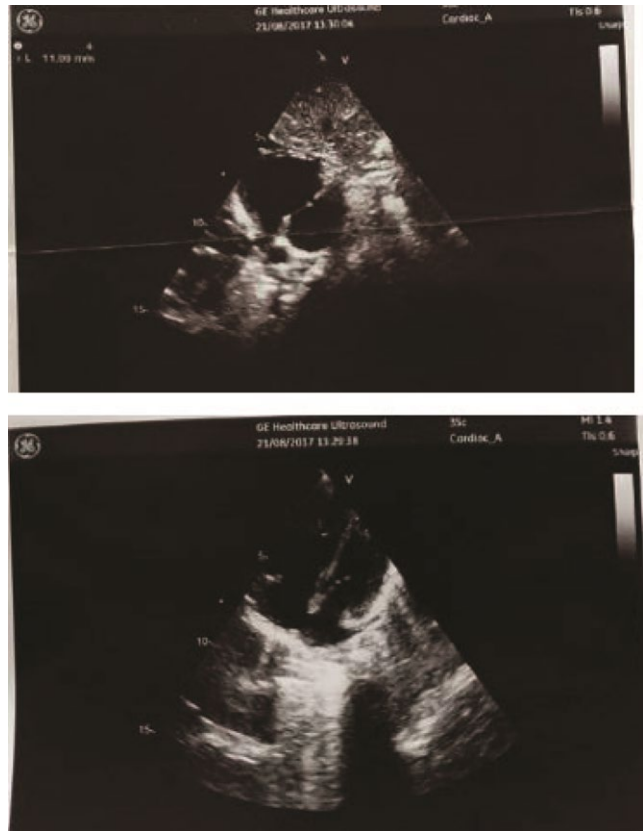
Cardiac defect analyses: the echocardiogram image indicating the atrial septal defect
